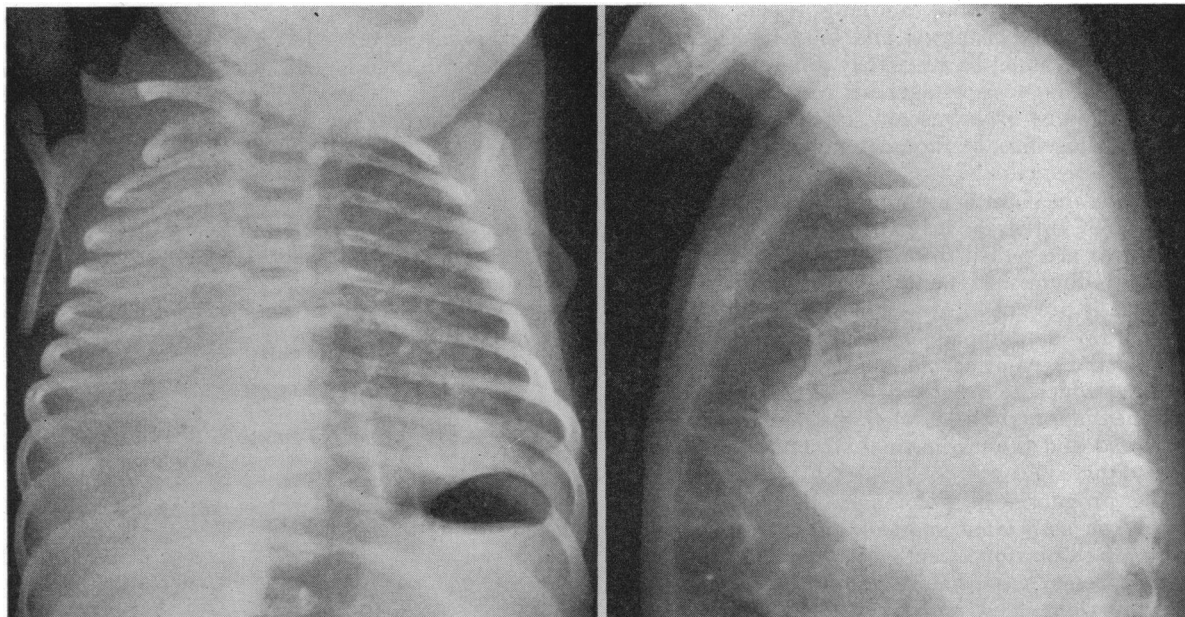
X-ray films showing herniation of the bowel through the anterior portion of the diaphragm and the absence of the right lung.
